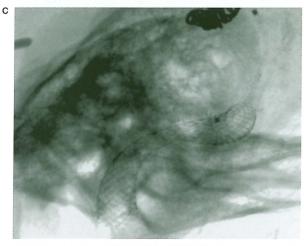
Lateral radiographs during angioplasty and stent placement. A) Shows the inflated PTA balloon within the left sigmoid sinus and internal jugular vein. B) Shows the stent within the sigmoid sinus and internal jugular vein before post-dilation of the stent. C) Shows the final result after stent placement and post-dilation.
